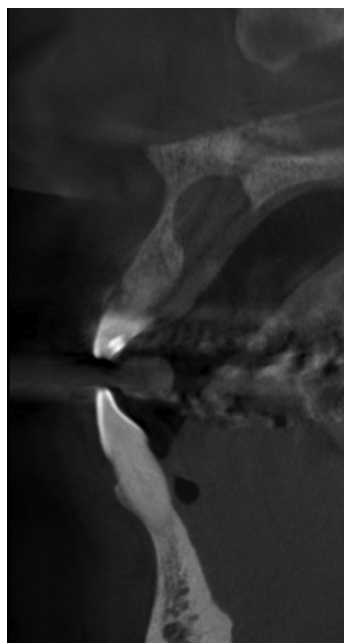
Cone beam computed tomography sagittal image demonstrating labial bone thinning and palatal bone thinning or perforation in the area of the nasopalatine canal.
